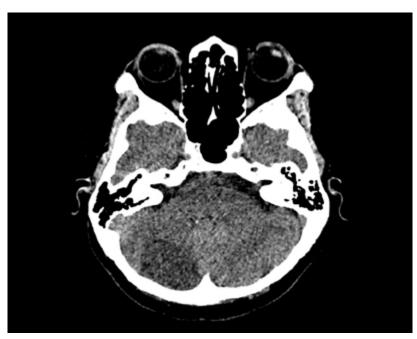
Single phase computed tomography study. Axial section of the posterior fossa in brain tomographic window. There is evidence of hypodense lesion in the right cerebellar hemisphere, with ovoid morphology, non-homogeneous appearance. There is no significant mass effect on the fourth ventricle, nor calcifications inside it
